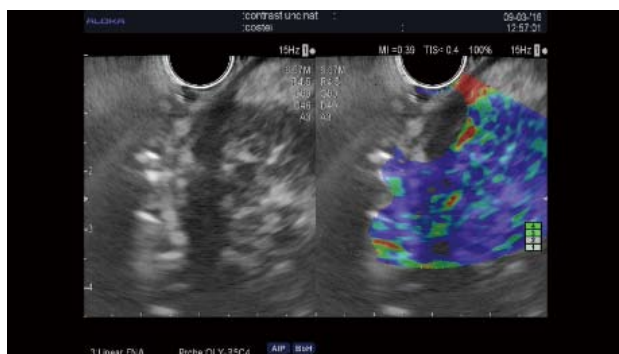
Elastography of pancreatic neuroendocrine tumor - qualitative assessment. Endoscopic ultrasound standard image (right) showing a well-delineated hypoechoic lesion of the head of the pancreas. The elastography image (left) exhibits a blue pattern in this neuroendocrine tumor.
